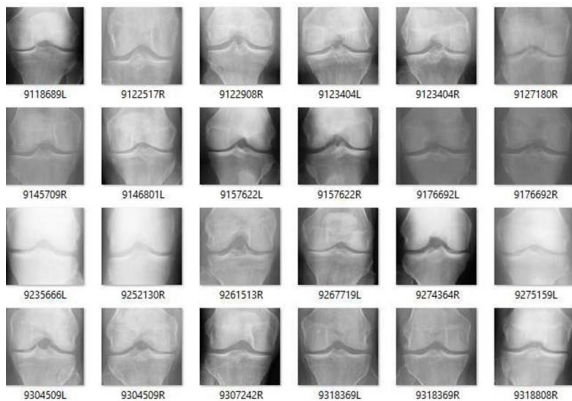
X-rays of minimal
